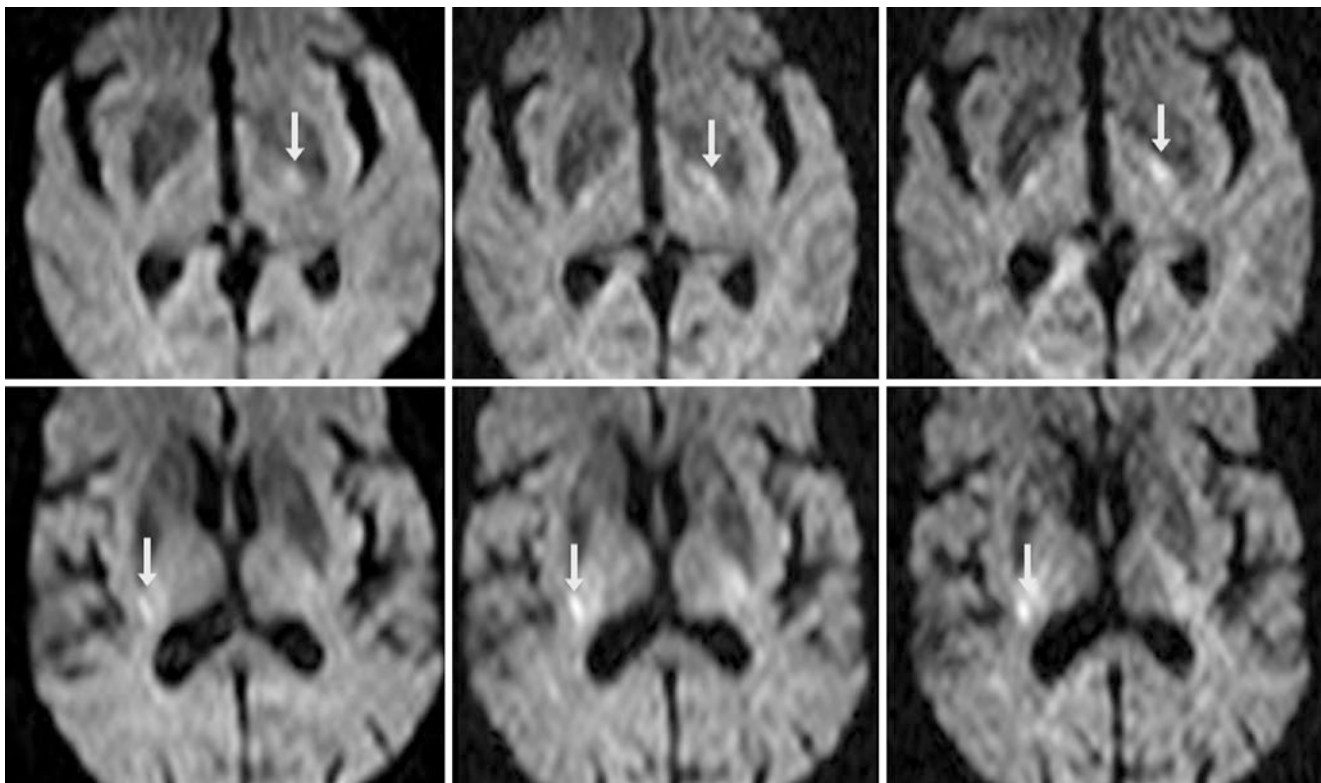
An 80-year-old with a 1.5 T MRI. There is increasing normal hyperintensity (from anisotropy in the craniocaudal direction) of the left PLIC/CST (arrows) on DWIs with b values of 1000 (top left), 1500 (top middle) and 2000 (top right) s/mm^2 . More superiorly, this occurs within
